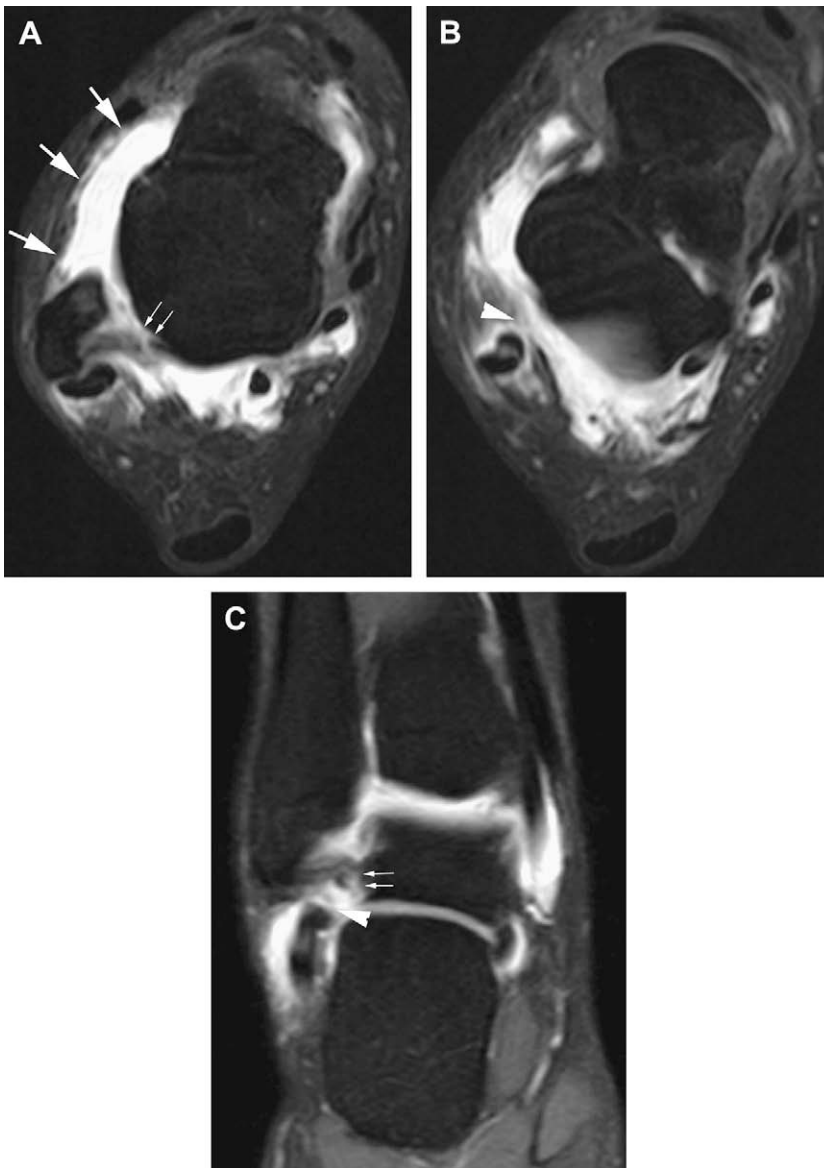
Chronic complete tear of the ATFL and CFL, and partial disruption of the PTF. (A–C) Axial and coronal fat suppressed T1-weighted MR arthrogram images of the right ankle show complete absence of the ATFL (*arrows in A*), complete rupture of the CFL with contrast communication with the peroneal tendon sheath (*arrowheads in B and C*), and partial disruption of the PTF at the insertion on posterolateral tubercle of the talus (*small arrows in A and C*).
